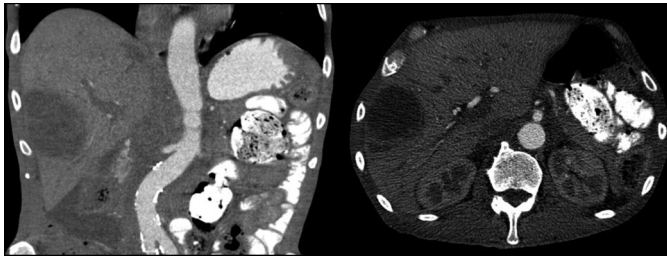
Abdominal computed tomography scan showing a $4.6 \times 4.5 \times 5.7$ cm multi-lobulated complex cystic mass in the right lobe of the liver.
